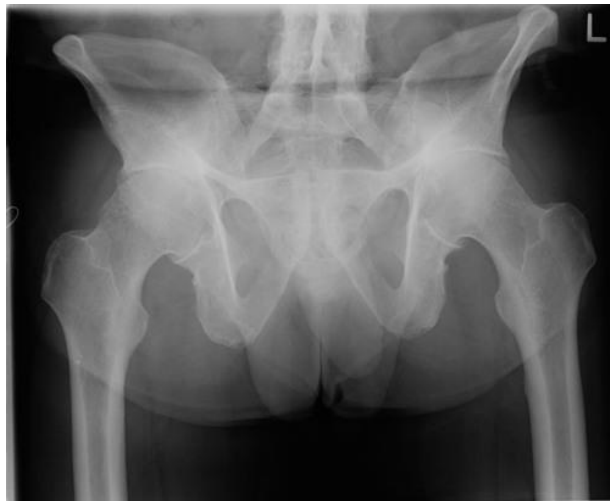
X-ray of pelvis showing bilateral coxite on AS
